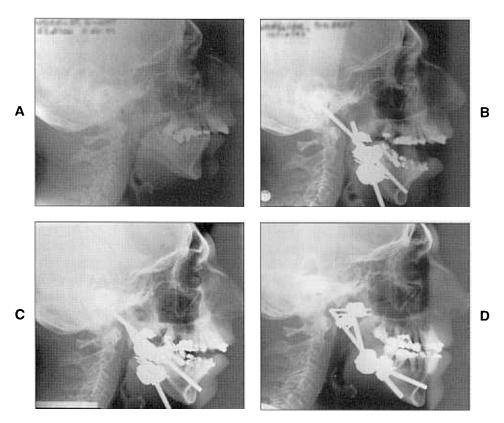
A patient with an obliquely placed distraction device. A, Pretreatment lateral cephalometric radiograph. B, Posterior occlusal interferences during linear activation of the distraction device resulted in an anterior openbite. C, Lateral cephalometric radiograph after introduction of vertical elastics. D, Lateral cephalometric radiograph after closure of the anterior openbite.
